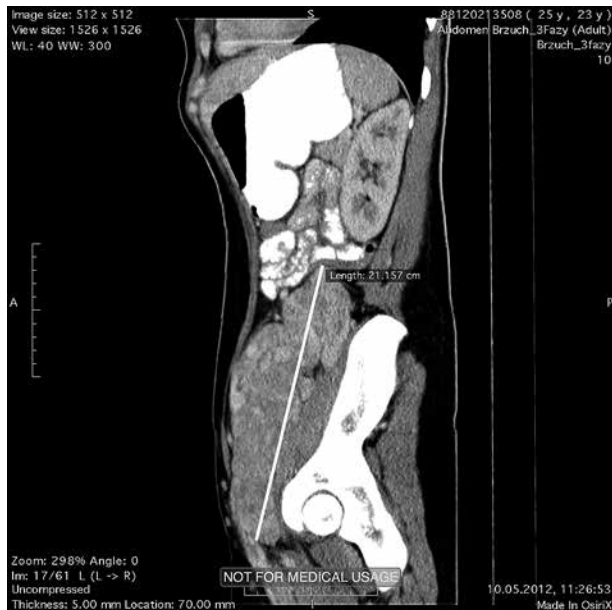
CT scan of the abdomen showing a 21 cm mass in the retroperitoneum
